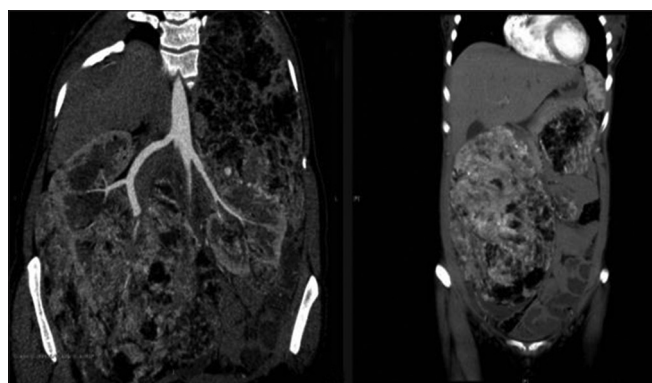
Pre-operative computed tomography angiogram-highly vascular angiomyolipoma
